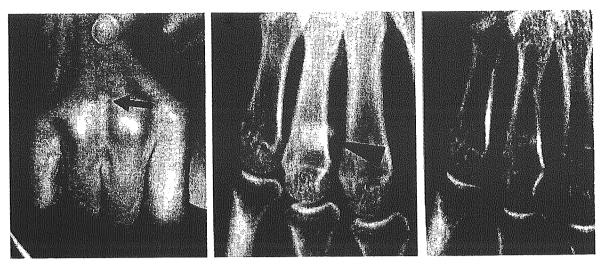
Left panel, subcutaneous nodule with pain (arrow). Radiographic examination before (middle panel) and after 3 months on etidronate (right panel). Arrowheads indicate the positions of nodular calcification.
